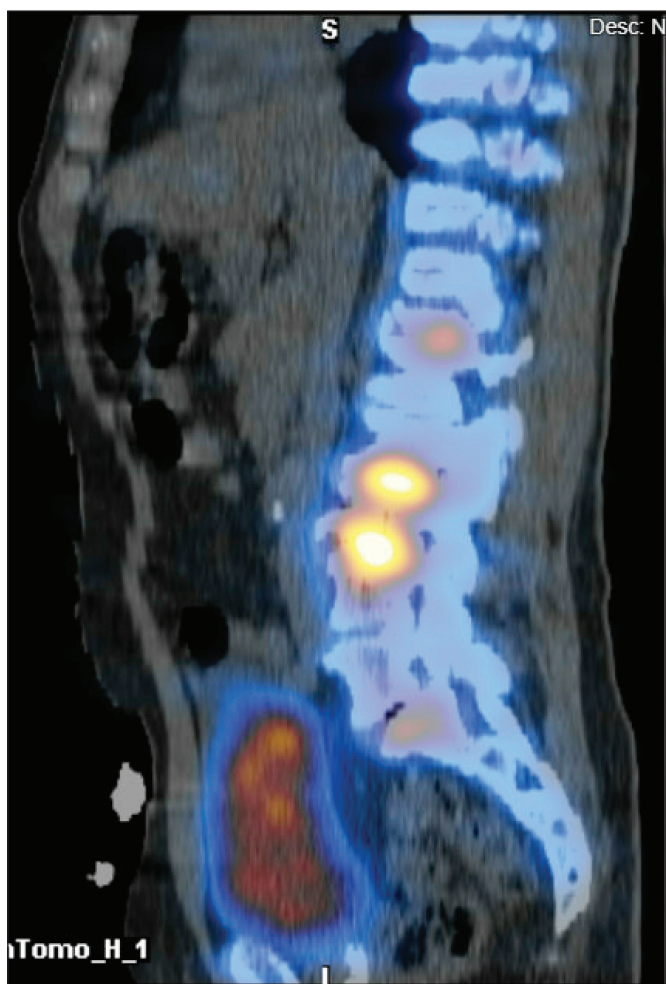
71-year-old male who had a Lumbar MRI performed, which demonstrated multilevel degenerative disc disease as well as multilevel neural foraminal stenosis at L2-L3, L3-L4, and L5-S1 bilaterally. SPECT/CT demonstrated metabolic activity at multiple levels, including T12-L1, L2-L3, and L3-L4, though the greatest degree of tracer uptake was noted at L3-L4 end plates. He had an L2-4 prone trans psoas lateral fusion and was followed up with 1 year later. He reported his pain level to be at a zero at his 1-year follow-up.
